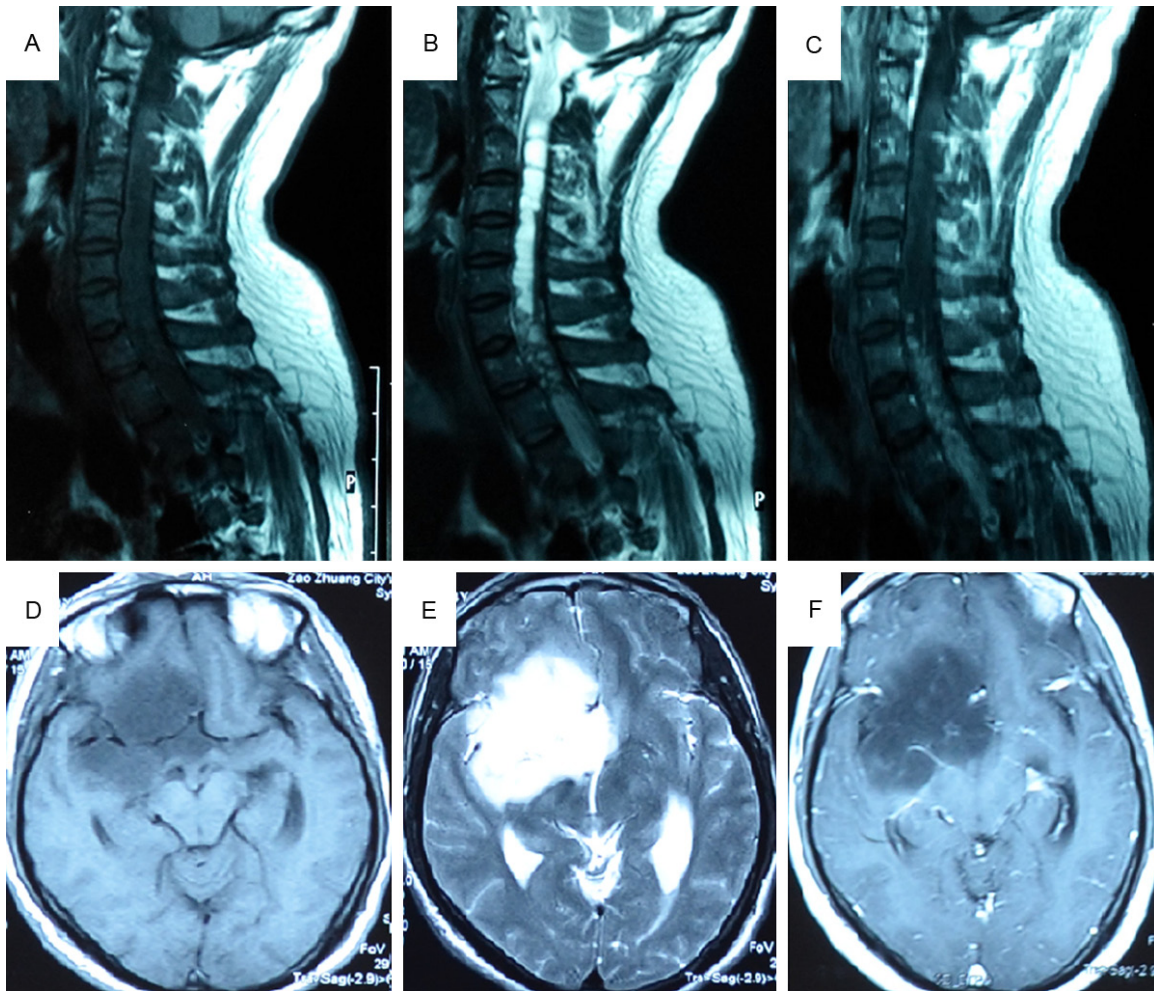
Neuroradiologic characteristics. Shown in panels (A-C) are the MRI features of case 2 as seen at presentation in T1-weighted, T2-weighted and post-gadolinium T1-weighted studies, respectively. These demonstrate a solid lesion that was low intensity on a T1-weighted image (A) and high intensity on a T2-weighted image (B) between T1 and T6, and an enhanced lesion with gadolinium between T1 and T6 level (C). Shown in panels (D-F) are the MRI features of case 3 as seen at presentation in axial T1-weighted, T2-weighted and post-gadolinium T1-weighted studies, respectively. These demonstrate a solid lesion that was hypointense on T1-weighted MRI (D), hyperintense on T2-weighted MRI in right frontotemporal, insular lobe and basal ganglia region (E), and no gadolinium enhancing was found (F).
